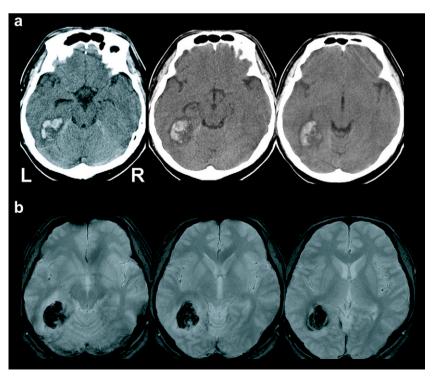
(a) CT scan on admission. (b) T 2* MRI 4 days after onset showing a hemorrhage in the left basal occipito-temporal region.
